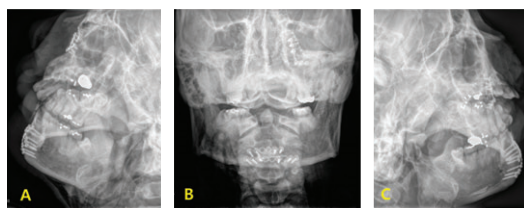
Postoperative Skull x-ray photo showing open reduction and internal fixation on panfacial fracture.
